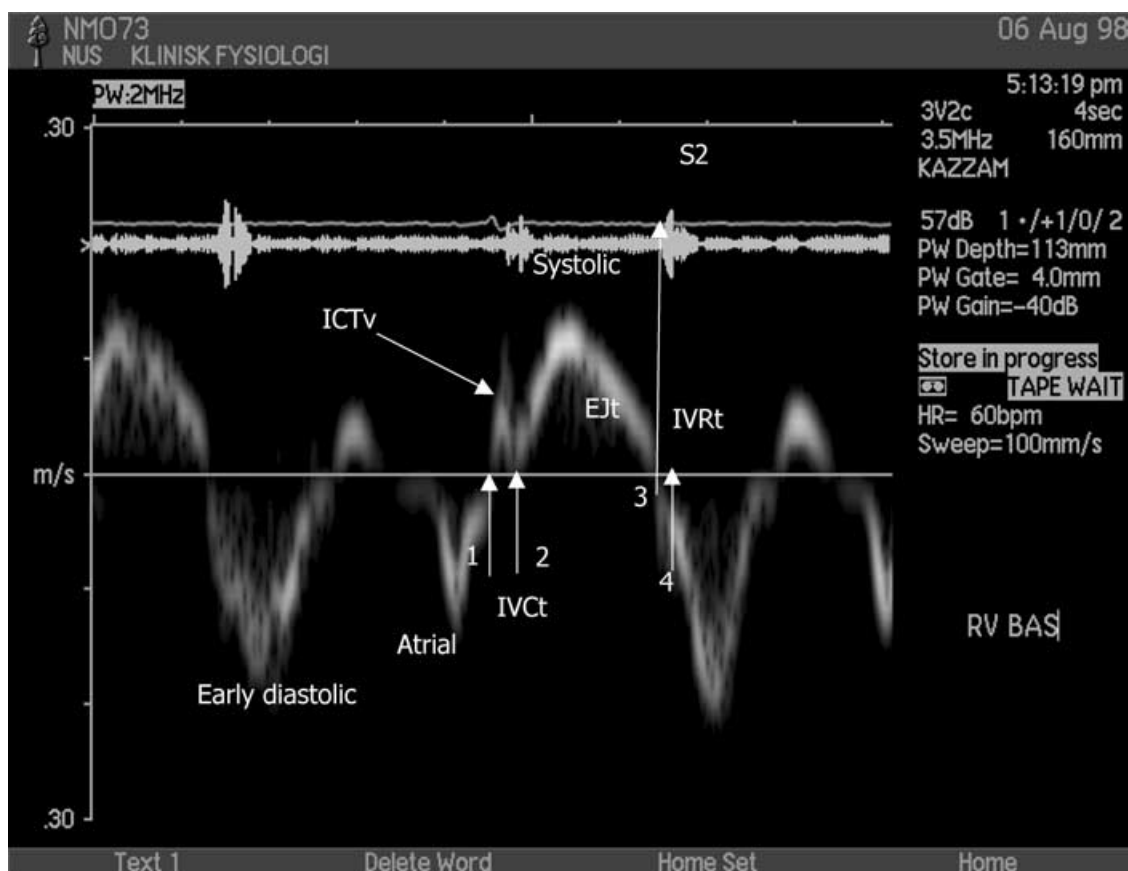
Analyzed parameters from pulsed Doppler tissue imaging.
